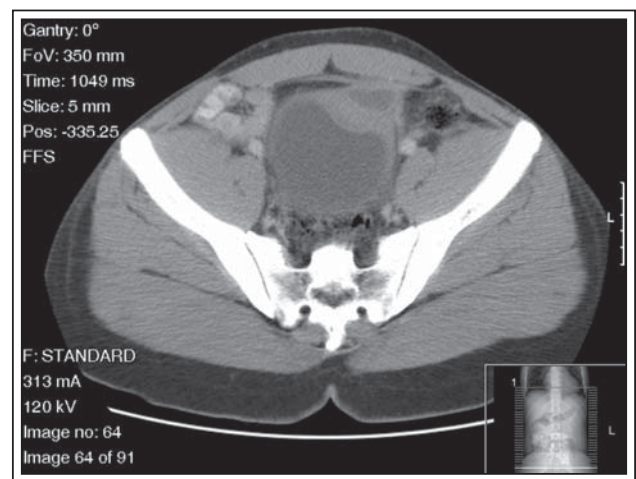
CT transverse image showing wall thickening with a pouch at the anterior superior aspect of the urinary bladder (arrow), suggestive of a urachal cyst.
